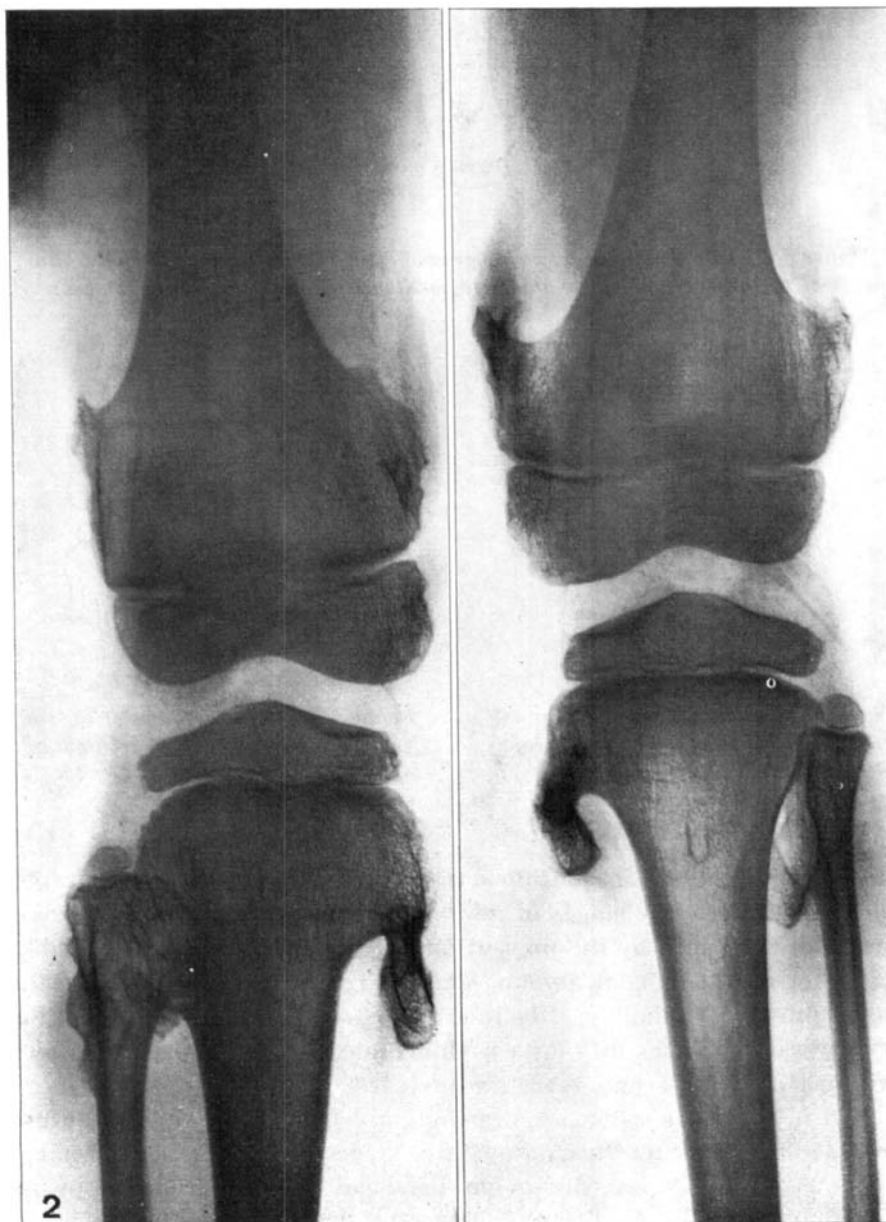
Radiograph of the same knees as seen in Figure 1. Age six years.
